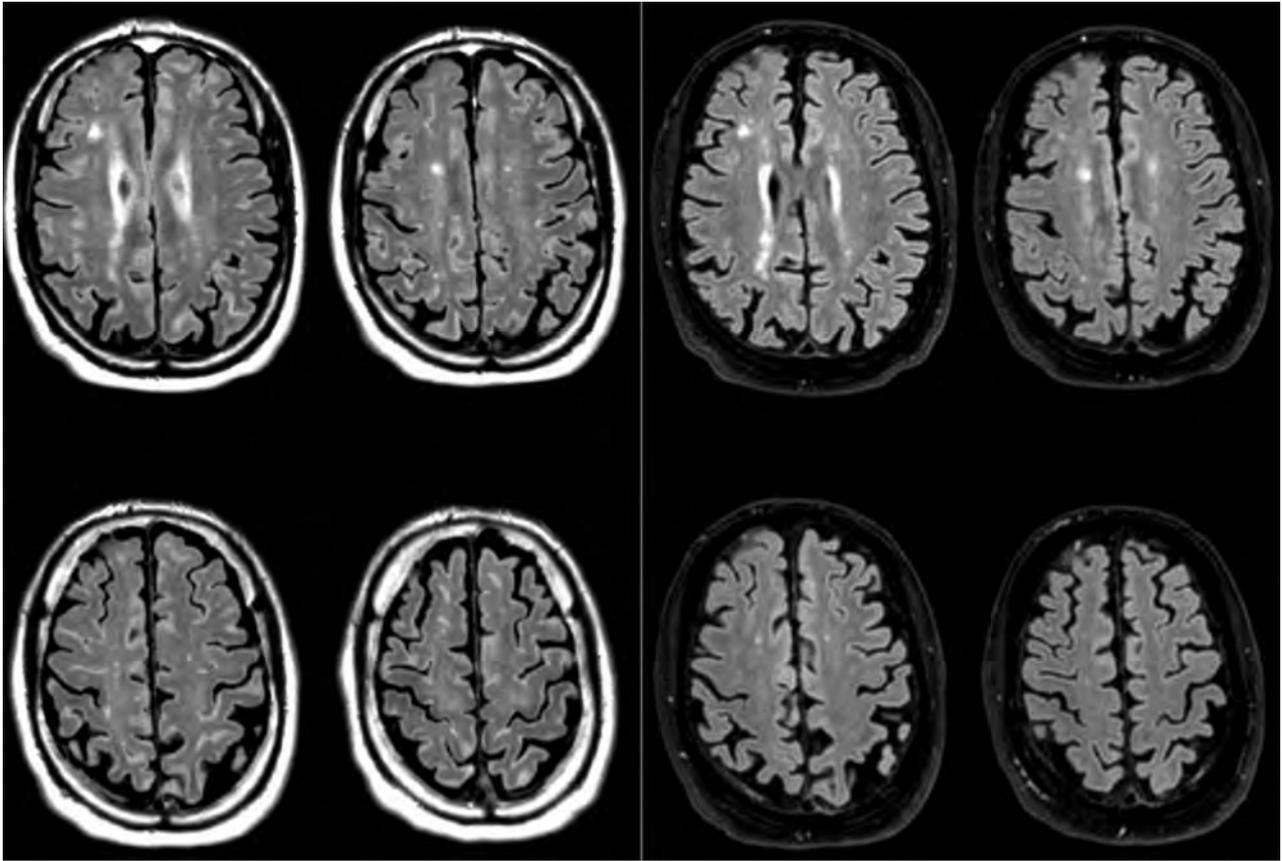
Four consecutive sections acquired with a synthetic MR imaging T2 FLAIR sequence (left) and a conventional FLAIR sequence (right) in the same patient at the same time. Note hyperintensities within and adjacent to the cerebral cortex on the synthetic sequence mimicking a subarachnoid hemorrhage. These abnormalities disappear on the conventional FLAIR sequence.
